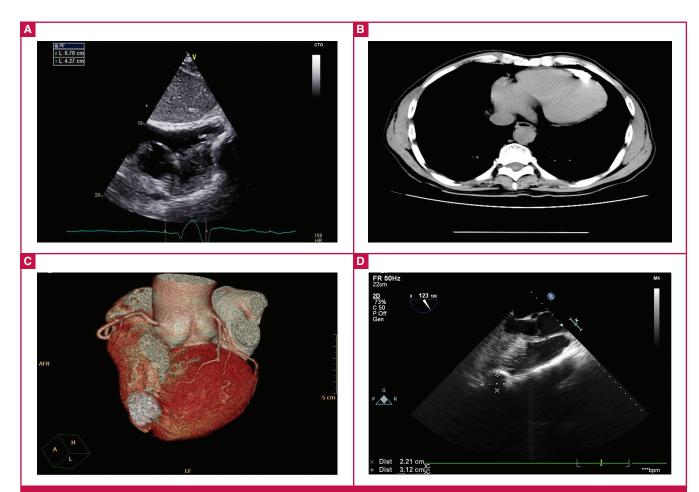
Findings on pre-operative imaging. (A) Transthoracic echocardiography showed a 4.3×0.7 -cm area of calcification within the myocardium on the anterior wall of the right ventricle near the apex at the subcostal window. (B) Cardiac computed tomography revealed a calcified pericardial mass in the apical area that extended to the anterior free wall of the right ventricle. (C) Coronary angiography showed normal coronary arteries but a calcified pericardial mass at the distal portion of the left anterior descending artery as an incidental finding. (D) Transoesophageal echocardiography identified a calcified mass measuring 3 × 2 cm in the apical interventricular groove that extended to the anterior wall of the right ventricle at the middle of the oesophageal view of 123°.
